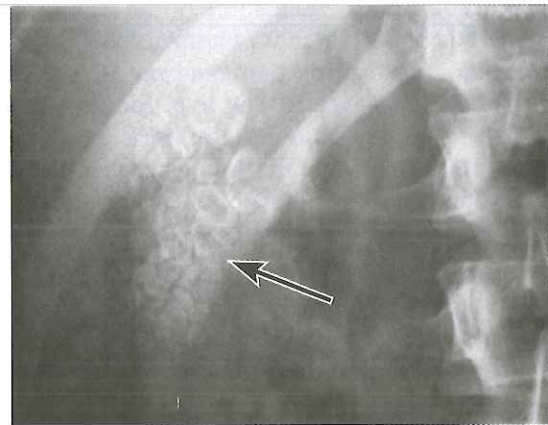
Radiograph of a gallbladder that contains gallstones (arrow).
